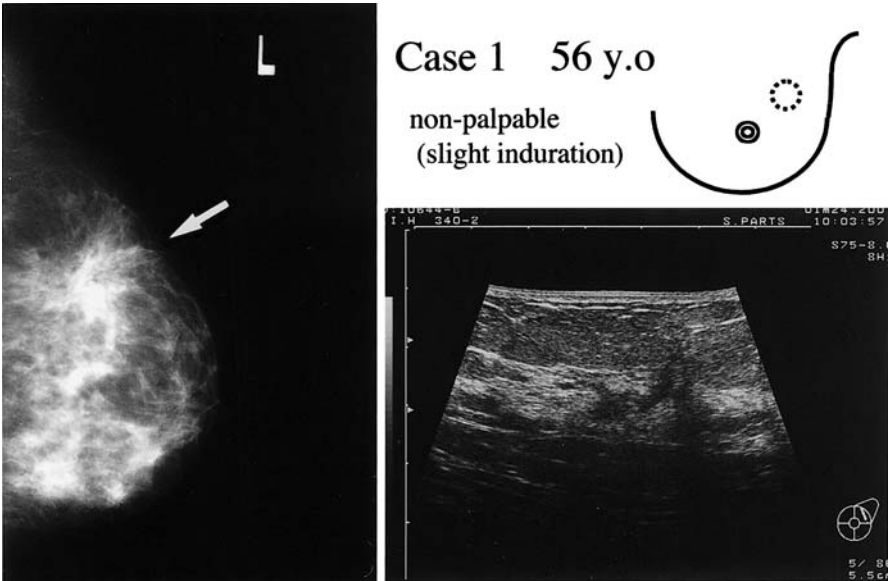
Focal distortion in mammography (MMG) (arrow); irregularly shaped hypoechoic area seen by ultrasonography
